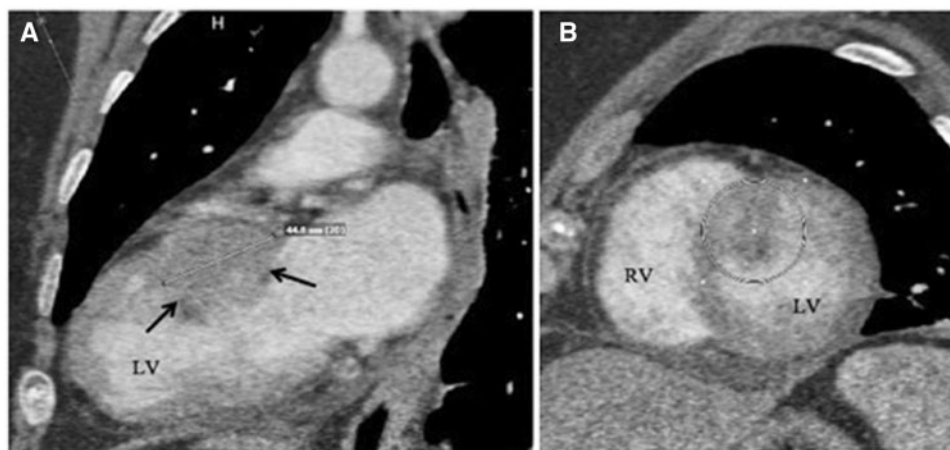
Computed tomography angiogram of Thorax. (A) Sagittal reconstruction. Arrows trace inferior outline of the anterobasal hypointense filling defect in the left ventricle, with radiographic measurement pictured (approximately 4.5 cm in longitudinal diameter); (B) Axial slice, short-axis view. Circle outlines the filling defect noted anteriorly in the left ventricle. LV, left ventricle; RV, right ventricle.
